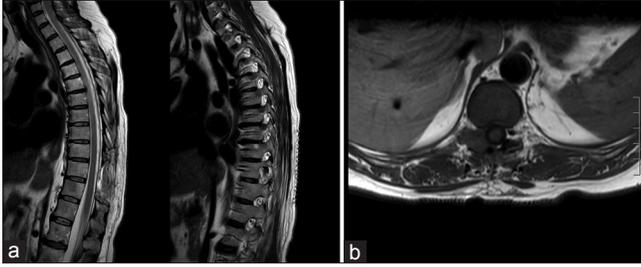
Postoperative sagittal (a) and axial (b) T1-weighted magnetic resonance imaging sequences documented a complete removal of the lesion.
